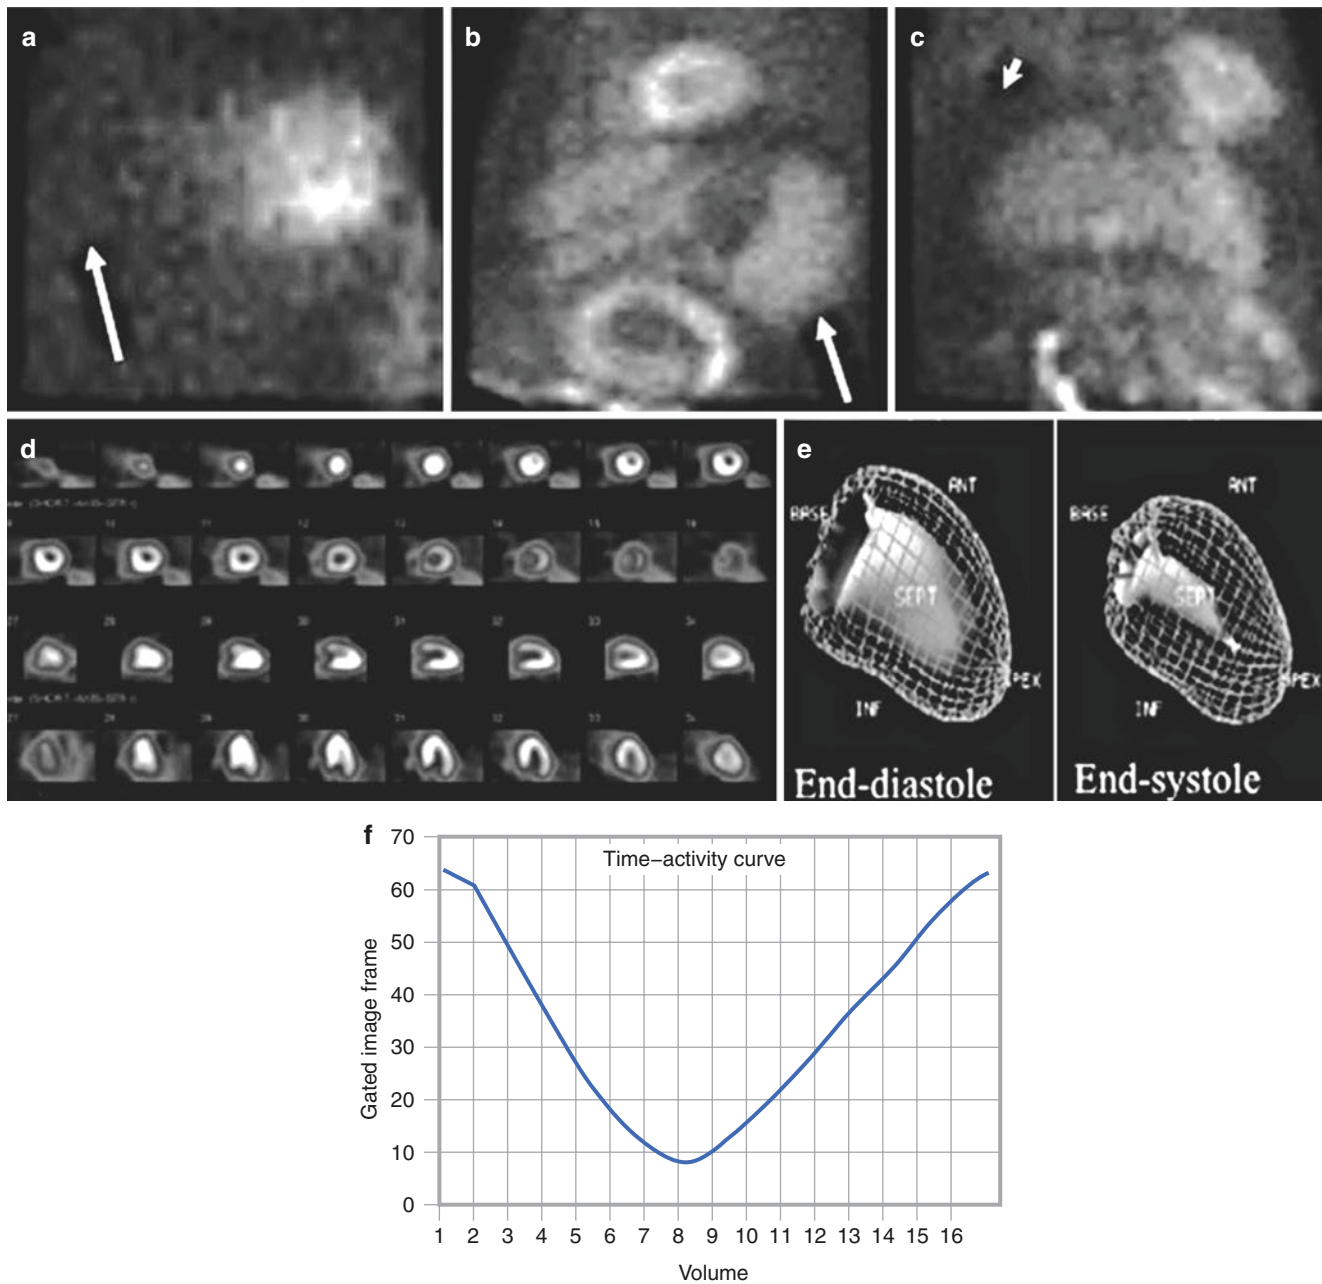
One of the more recent reported utilities for preoperative pharmacologic stress imaging has been in combination with functional myocardial perfusion imaging [25] or cardiac MRI [88] in end-stage liver disease patients being risk stratified before liver transplantation. Regadenoson, adenosine, or dobutamine can all be safely used in this high-risk, critically ill surgical population. (a) Raw cine image showing a lack of tracer uptake in the cirrhotic liver (*arrow*). (b) Evidence of an
